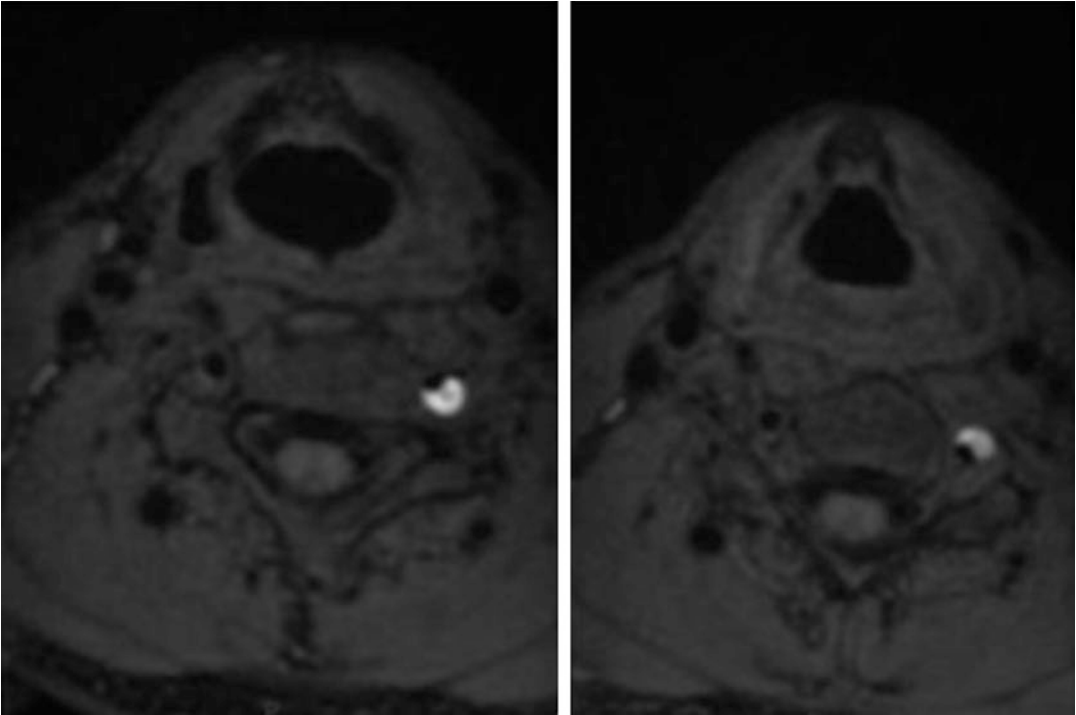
Fat-saturated T1 axial images in MRI: left vertebral artery dissection (intramural hemorrhage seen as hyperintensity)
